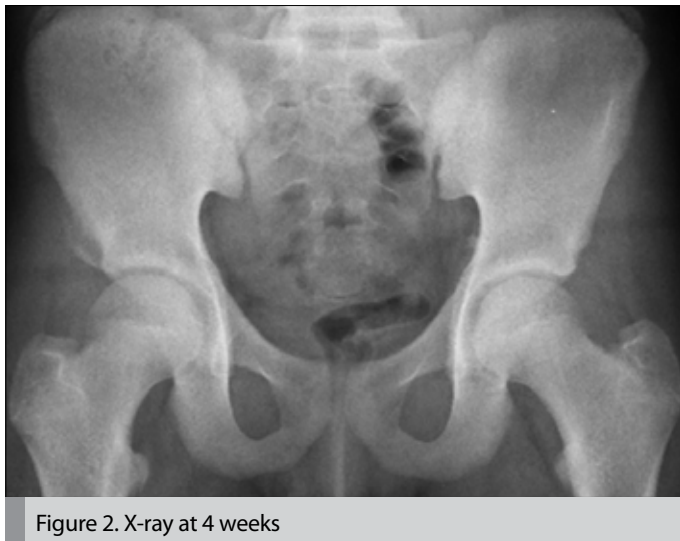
X-ray at 4 weeks
